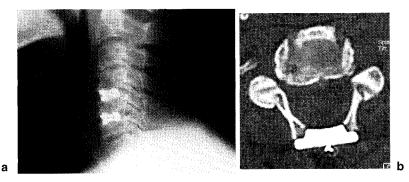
a Lateral X-ray demonstrated anterior cervical fusion with threaded cages at C4-C5 and C5-C6. b Postoperative computed tomography (CT) shows bilateral open-door cervical expansive laminoplasty with hydroxyapatite spacers and titanium screw
